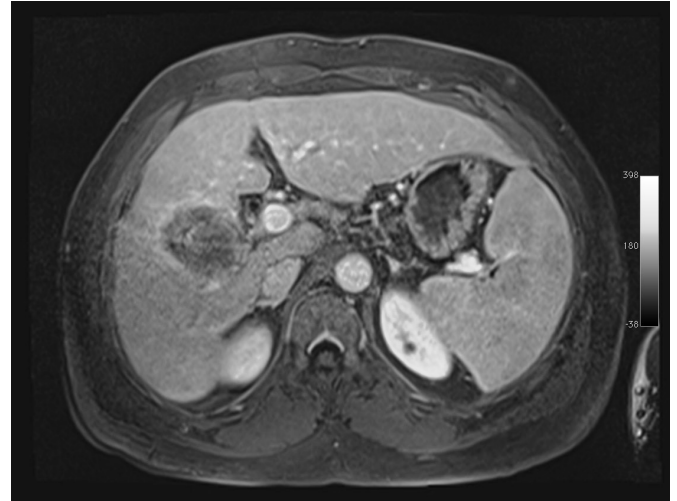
Liver MRI – T1 with injection, portal phase. After cryotherapy (no more residual tumor).
